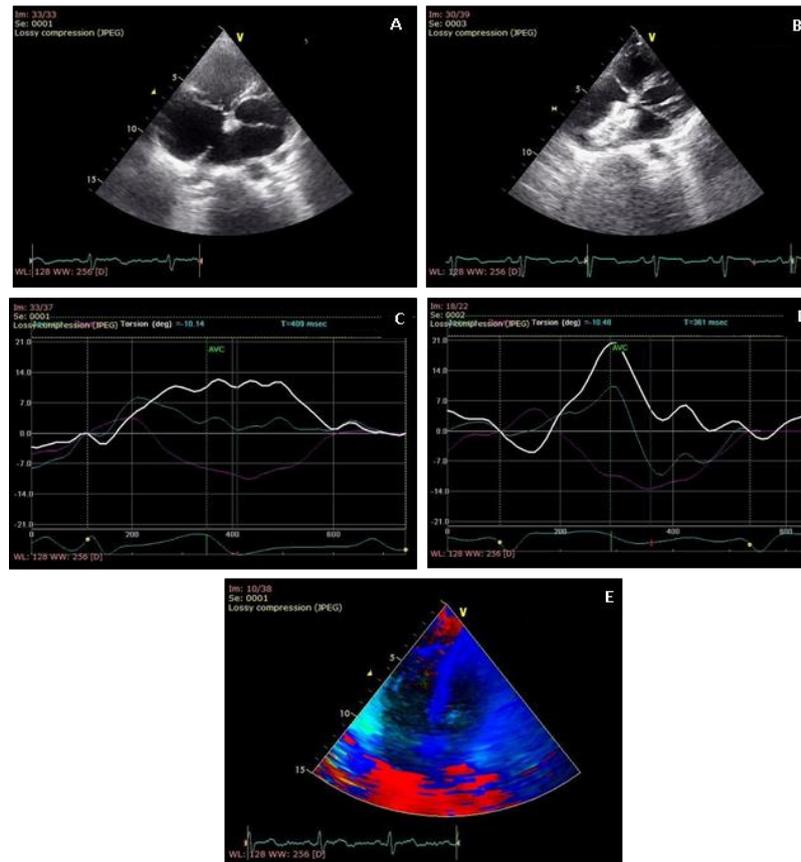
Transthoracic Echocardiographic Data One Day Prior to ASD Device Closure A. 2DE apical 4 chambers showing ostium secundum ASD.
